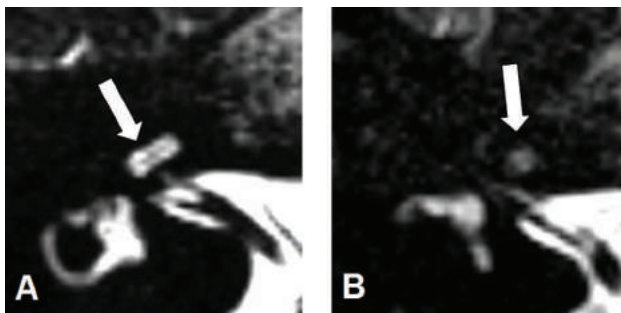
Axial 3D heavily T2-weighted MRI images showing a hyperintense signal within the cochlea indicative of a cochlear lumen containing fluid (A); loss of the hyperintense signal within the cochlea implicating severe loss of intracochlear fluid caused by fibrosis or ossification (B).
